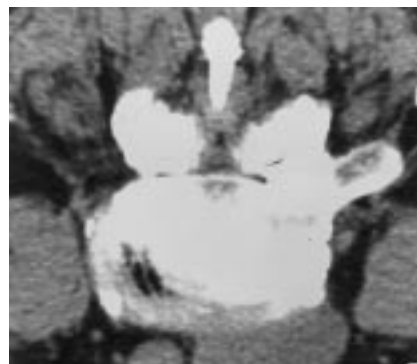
Computed tomographic scan demonstrates the relationship of the caudal sac and nerve roots and the very substantial facet degeneration. Note the marked narrowing of the lateral recesses.
